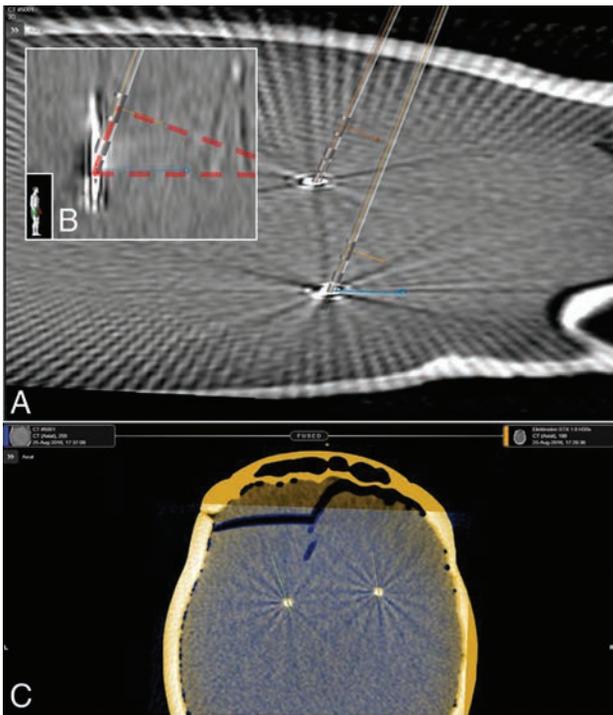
A, Visualization of 3D directional electrode models in a 3D reconstruction of rotational fluoroscopy imaging. The *blue line* (in-plane) indicates the detected orientation in the axial plane based on the iron sights method. The *orange line* originating out of the marker indicates the lead orientation. B, The same scene from a lateral view. The in-plane orientation and marker orientation form a *rectangular triangle* (red transparent) with the right angle at the marker. C, Fusion of rotational fluoroscopy 3D reconstruction and the CT scan in Brainlab Elements (Brainlab, Munich, Germany).
